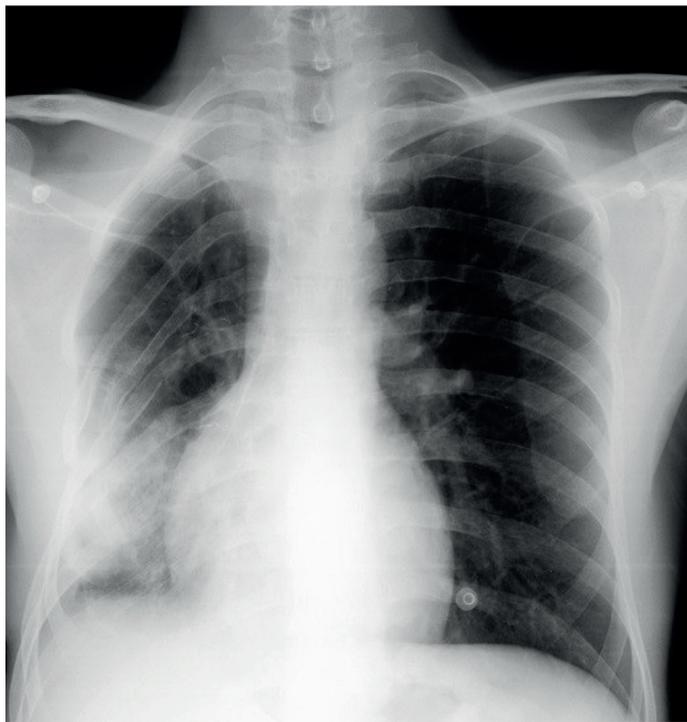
PA chest x-ray view showing deformity in the right, 4, 5, and 6th ribs and consolidation in the right middle zone
